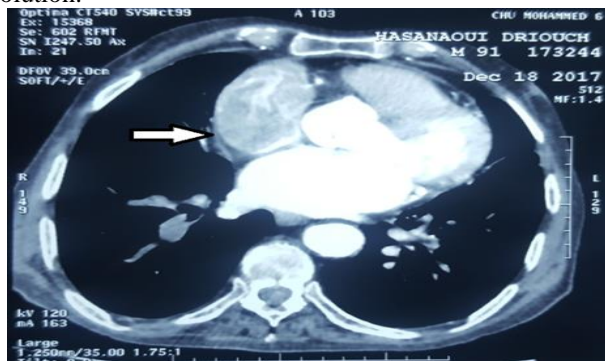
CT Scan: right atrial thrombus (white arrow).
